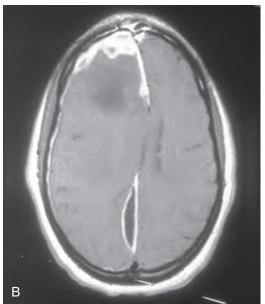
(A) T1-weighted axial magnetic resonance image of the brain showing a hypodense mass in the right frontal region with marked meningeal thickening, midline shift, and effacement of the right lateral ventricle. (B) T1-weighted axial magnetic resonance image of the brain in the same patient with gadolinium enhancement showing abnormal enhancement. Posteriorly, there is an elliptically shaped density in the interhemispheric fissure. (C) T2-weighted axial magnetic resonance image of the brain in the same patient, showing high signal intensity in the right frontal region and interhemispheric fissure. (B from Tunkel AR, Scheld WM. Focal central nervous system infections. In: Root RK, ed. Clinical Infectious Diseases: A Practical Approach. New York: Oxford University Press; 1999:723–731.)
